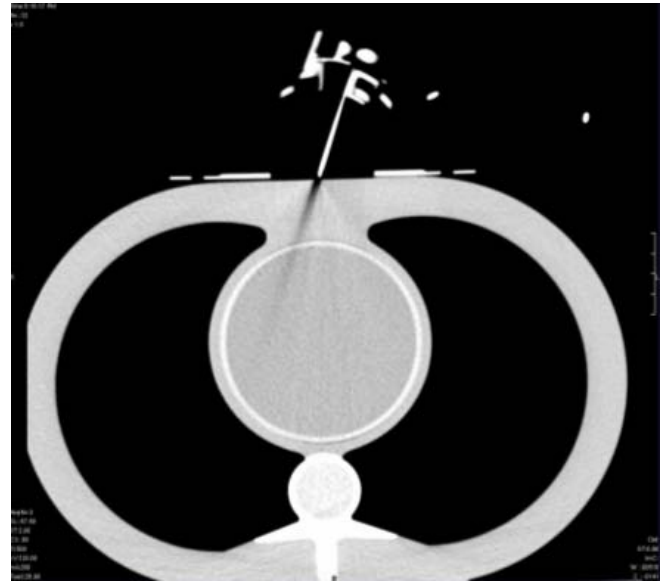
A CT scan of the device showing that no significant artifacts are produced.
